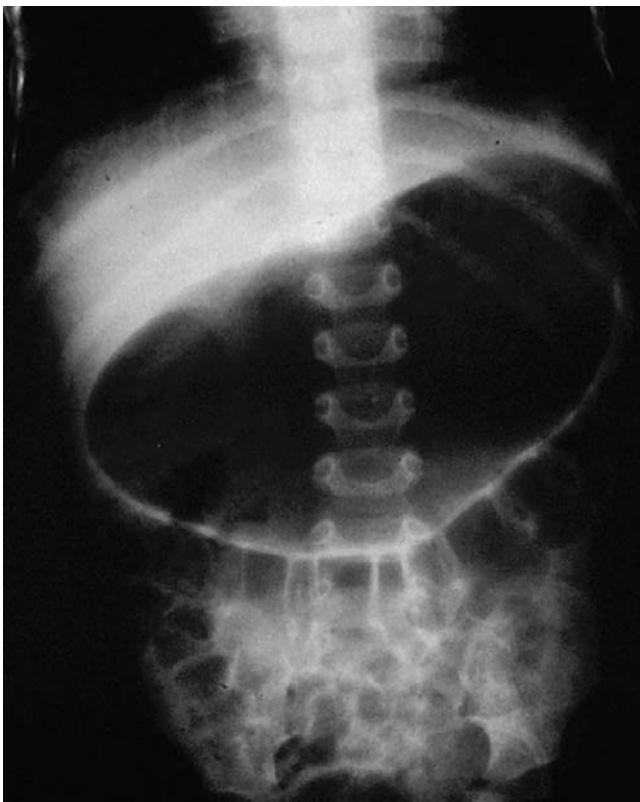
Radiograph of a patient with gastric distension. The patient's respiratory distress resolved once a nasogastric tube was inserted.
